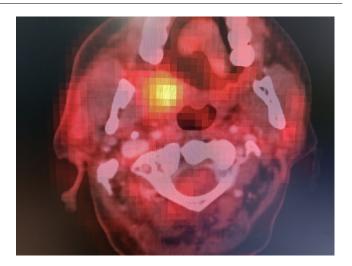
F18 FDG PET scan showing active metabolic lesion in palate
